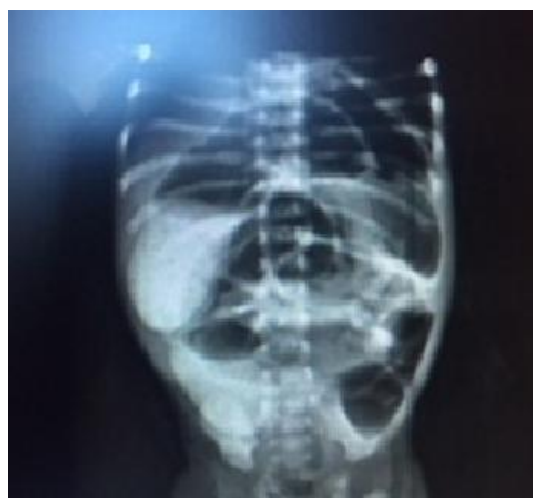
Supine radiograph of the abdomen of the patient showing that the bowels. Markedly dilate bowel segments with air-fluid levels and weakly a sign of pneumonitis intestinalis
